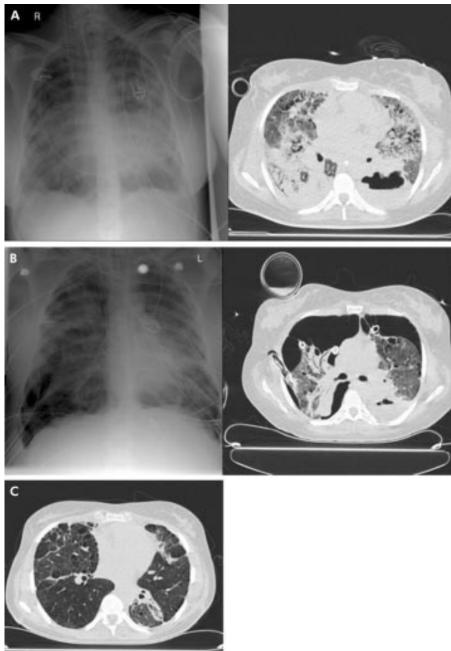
Radiology of a case of left lower lobe pneumonia complicated by ARDS. (A) Chest radiograph and CT scan taken on the same day 3 weeks after the onset of respiratory failure. An abscess is obvious in the apical segment of the left lower lobe on the CT scan. There is dense dependent consolidation bilaterally but elsewhere the lungs are affected in a patchy distribution. (B) Chest radiograph and CT scan taken on the same day 5 months after the onset of respiratory failure. Bilateral loculated pneumothoraces are evident despite the placement of several intercostal chest drains on both sides. (C) Chest CT scan taken 6 months after discharge from hospital showing diffuse emphysema and patchy areas of fibrosis
